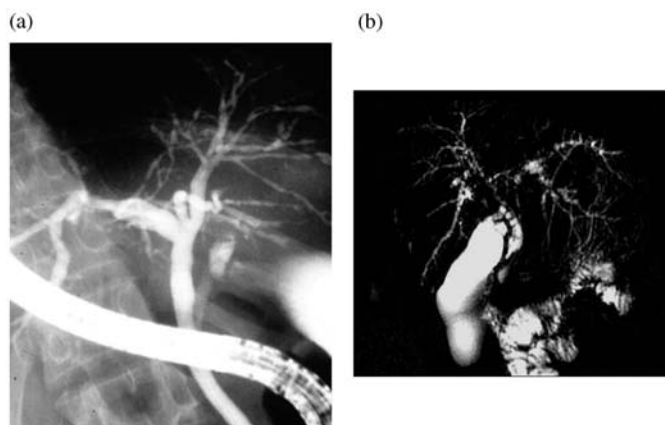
Sclerosing cholangitis – equivalent biliary imaging between primary and secondary disease: (a) classical appearance of primary sclerosing cholangitis by ERCP; (b) portal biliopathy secondary to portal vein thrombosis giving equivalent imaging by MRI.
